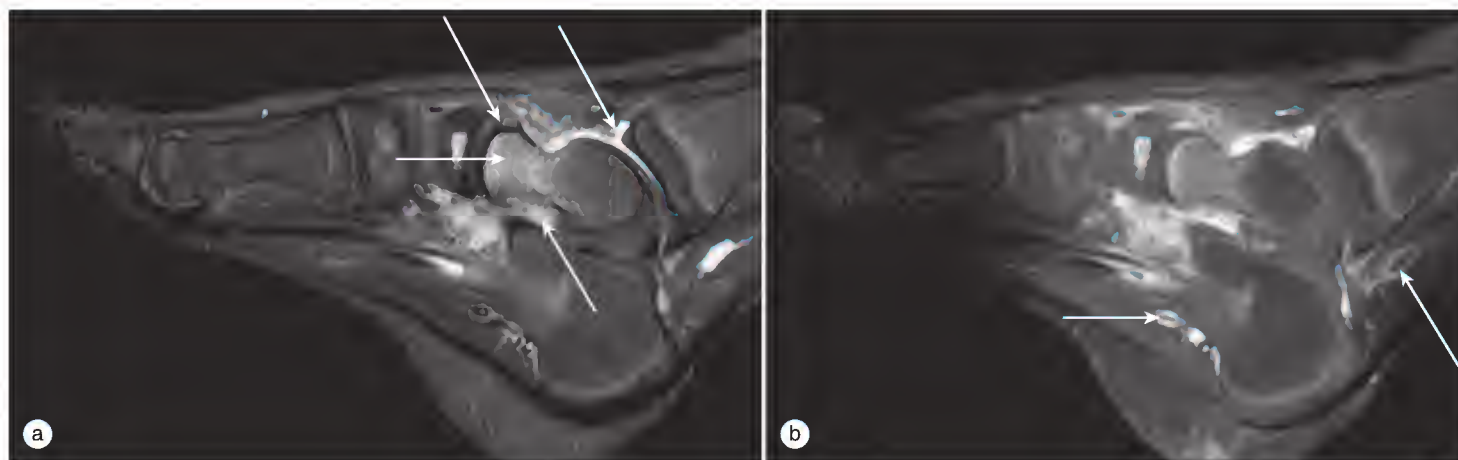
Magnetic resonance images of a swollen ankle in a 5-year-old boy. In addition to talocrural arthritis, joint fluid and synovitis are also present in the subtalar and the talonavicular joint (arrows). There is bone marrow edema of the talus on the short tau inversion recovery image (a). Fat-suppressed T1 image after administration of intravenous contrast (b) shows tenosynovitis (arrows).
